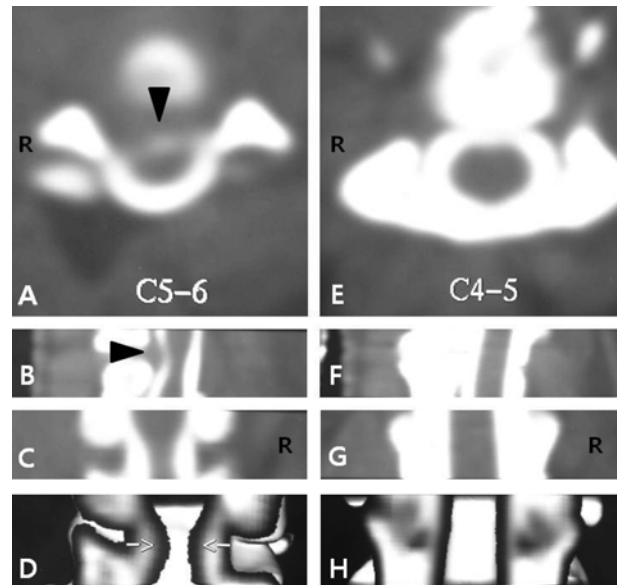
CT myelogram images from a 9-year-old neutered female Pekingese with neck pain at C5-C6 (A), (B), (C), (D) and C4-C5 (E), (F), (G), (H). (A), (E) present transverse view and (B), (F) present sagittal view. (C), (G) are dorsal view at the level of the articular processes and (D), (H) are 3D reconstruction at the same level. CT myelogram at C4-C5 shows the normal appearance of the spinal cord. (A), (B) show the ventral compression of the spinal cord (arrow head). (C), (D) reveal the dorsolateral compression of the spinal cord (arrow).
